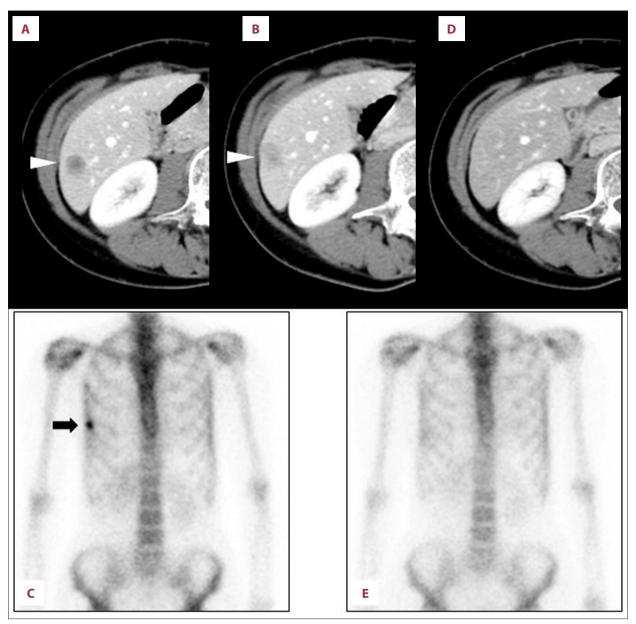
Changes in liver metastasis on E-CT and bone metastasis on bone scintigraphy. E-CT 6 years and 9 months after the first surgery (A) revealed liver metastasis (white arrowhead). Six months later, E-CT (B) showed the enlargement of liver metastasis (white arrowhead), and bone scintigraphy (C) showed bone metastasis in right 6th rib (black arrow). After 2 years and one month with oral S-1 chemotherapy, both liver and bone metastases disappeared on CT (D) and bone scintigraphy (E).
